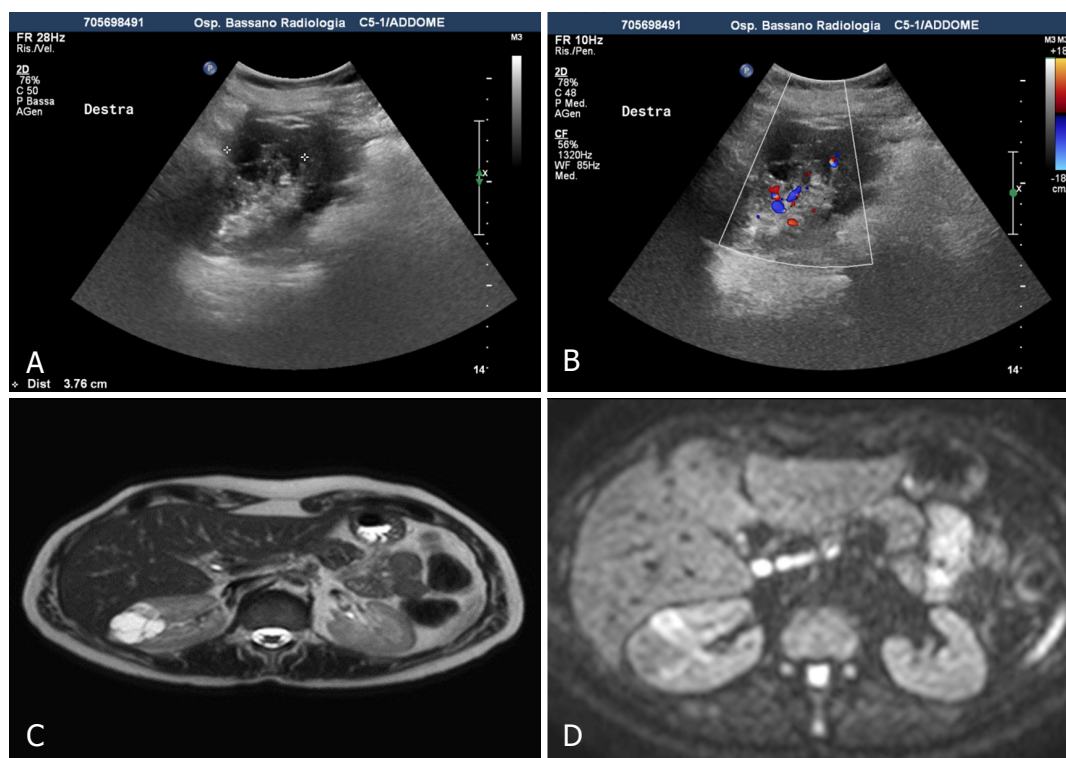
MRI with DWI. Greyscale sonography shows right midportion complex cystic, without vascularization at color-Doppler analysis (A, B). MR reveals on T2 weighted images complex cystic lesion (Bosniak III-IV) with multiple thin septa and hypointense intramural nodule (C). DWI weighted images show restriction of the intramural nodule: it was a papillary RCC (D). DWI: diffusion weighted imaging; RCC: renal cell carcinoma
